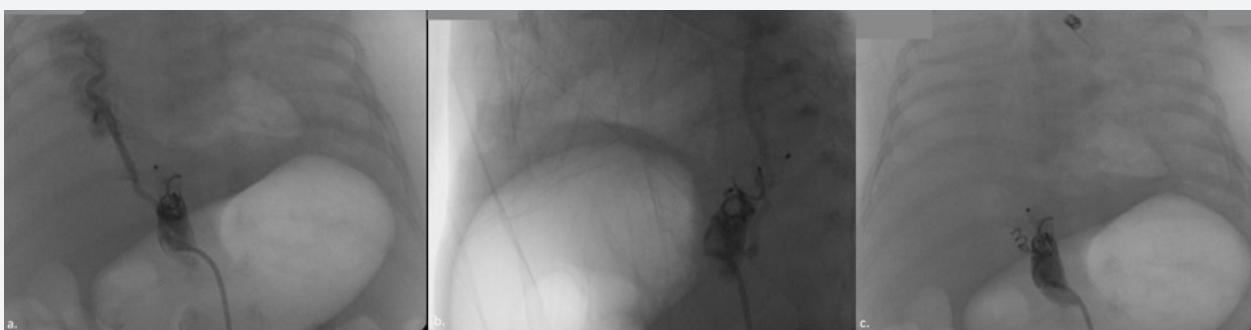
The control echocardiographic examination revealed the presence of residual flow through the AVP and scimitar vein and the patent ductus arteriosus type C (Figure 2a and 2b). Angiography of the anomalous vessel showed the presence of residual flow through the AVP4 (Figure 2c); AVP4 marks with an arrow.
